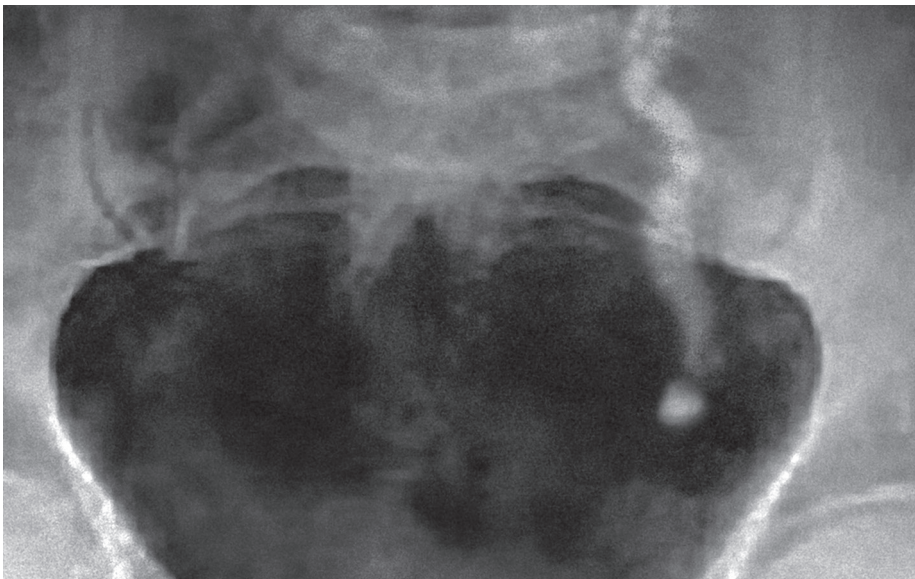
X-ray of the pelvis, showing renal colic caused by urolithiasis in the left ureter.
